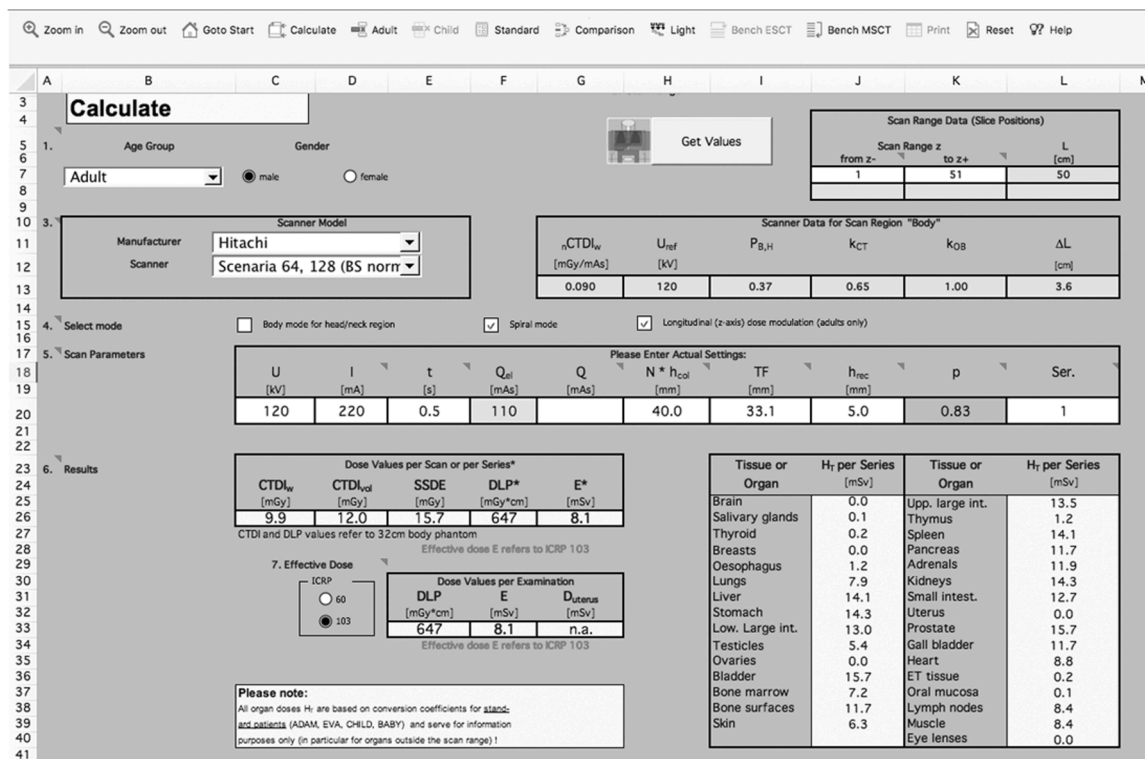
Spreadsheet of the “Calculate” module in CT-Expo software. Patient dose could be calculated after selecting patient type, defining scan range, selecting scanner model and scanning mode, as well as inputting scan parameters.
